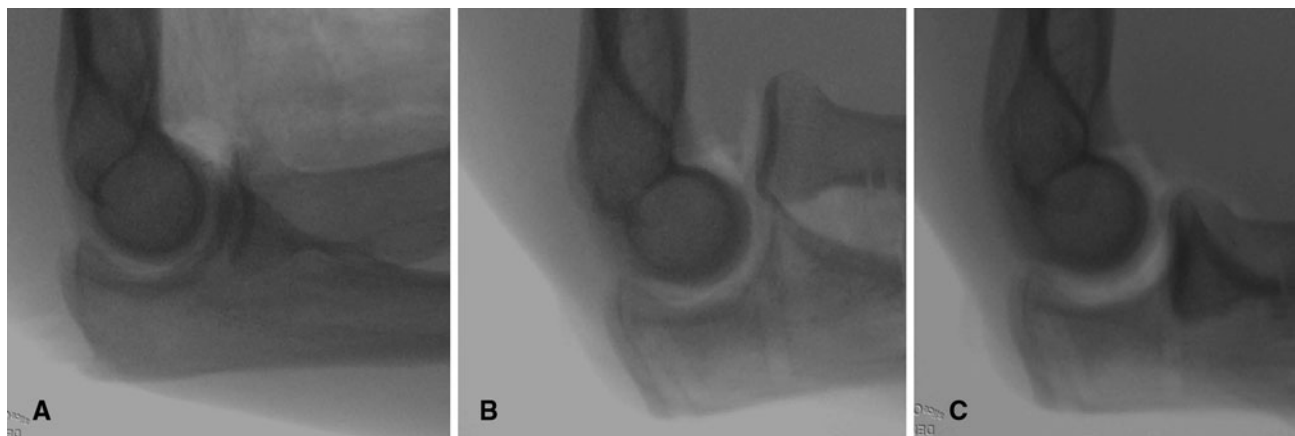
True lateral radiographs of (A) a nonsubluxated elbow, (B) anteriorly subluxated elbow, and (C) posteriorly subluxated elbow are shown.
